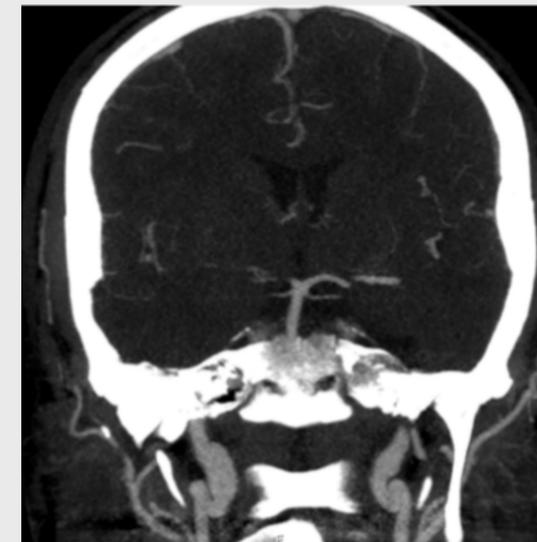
CT scan of same person as figure 1 showing bilateral ECAA
